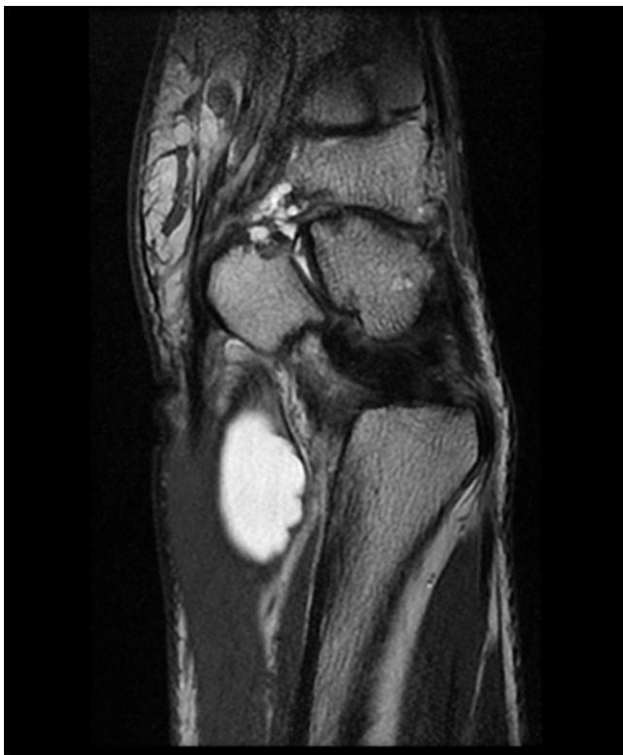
T2-weighted magnetic resonance image of patient's ganglion within Guyon's canal*
